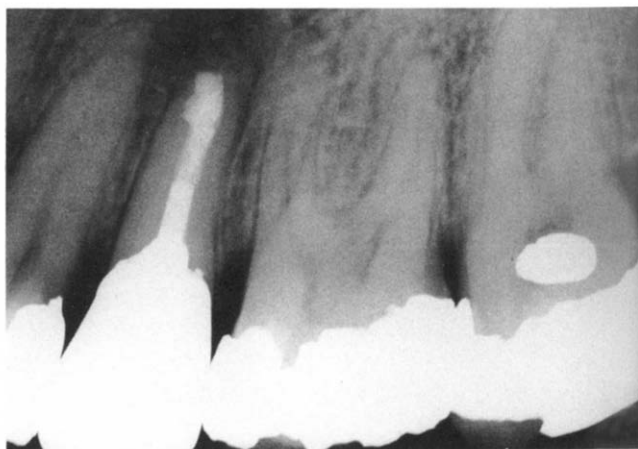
Immediate postsurgical radiograph. Note the gutta-percha material extending from the post to the root apex.
